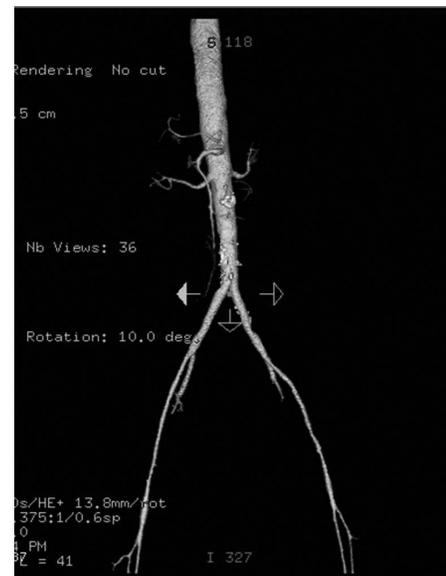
CT angiogram with 3-dimensional reconstruction showed patent mesenteric vessels.
